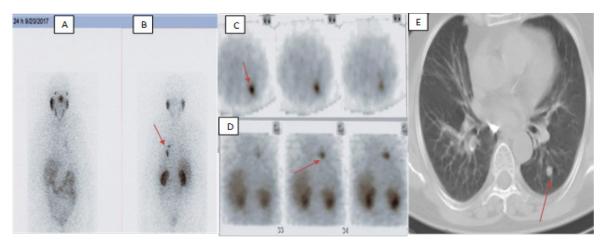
A anterior planar, B posterior planar, C transaxial SPECT, D coronal SPECT and E computed tomography images of the patient No 8. Images A-D are obtained 24 hours after IV injection Lu177-PSMA. The abnormal focus is shown with red arrow in each image. Abnormal activity in the base of the left lung indicates lung metastasis which was confirmed in CT scan images.
